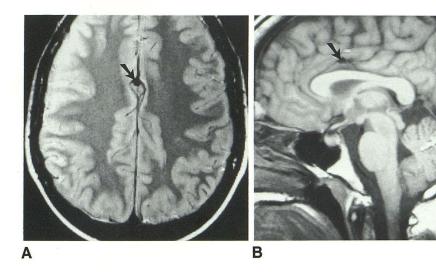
A and B, Axial 3000/20/1 and midline sagittal 400/15/3 SE MR images demonstrate a prominent midline vessel in the course of the pericallosal artery with an apparent aneurysm at its trifurcation (arrows). Note is also made of a cerebellar vermian lipoma on the sagittal image.
